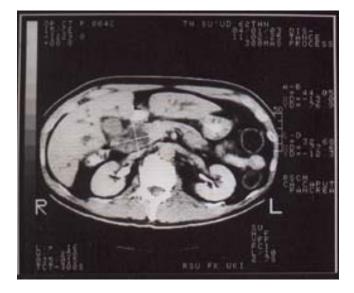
Computed Tomographic Scan of upper abdomen shows a mass in the head of the pancreas.
